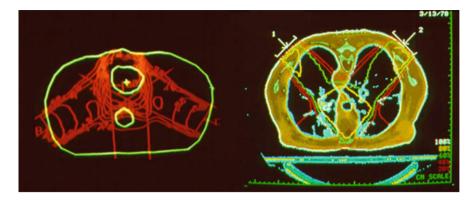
Examples of data output from the computer-assisted treatment planning systems developed at LLUMC in the 1970s. The image from the first (ultrasound) planning system, for a patient treated in 1973, is shown at *left*; a planning image from the second LLUMC system, which employed CT scans, is shown at *right* for a patient treated in 1978. In addition to reproduction of the patient's anatomy, the CT-based system allowed assessment of density variations as the X-ray beams passed through tissue
